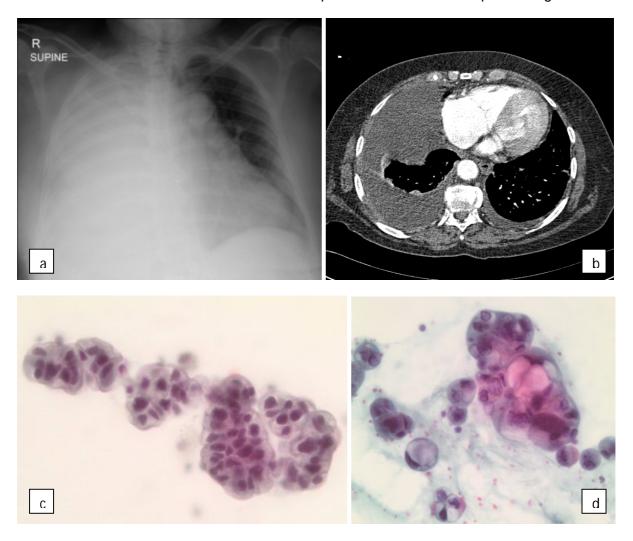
Involved mediastinal lymph nodes with large right sided pleural effusion on chest X-ray (a) and CT (b). Sputum - malignant. Cells seen in balls with abundant, clear, vacuolated cytoplasm (c). Pleural effusion - Metastatic adenocarcinoma (d).
